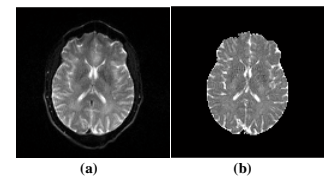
T2-weighted image (a) and corresponding T2 map (b) generated from 4 echoes of the same single excitation multi-echo data set as in Fig.2c.
